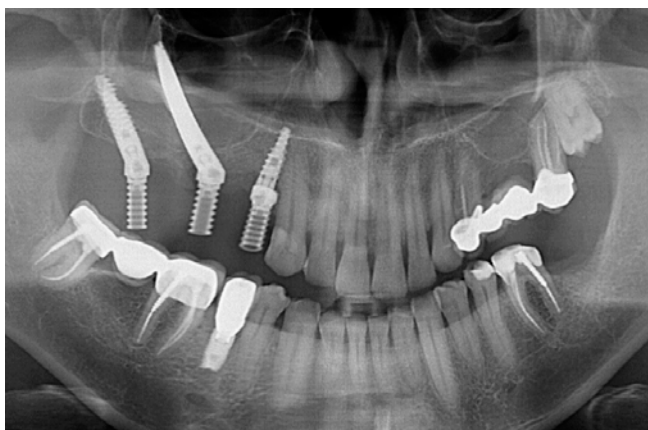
Orthopantomogram with 3 implants on the maxilla, placed for immediate denture loading.
